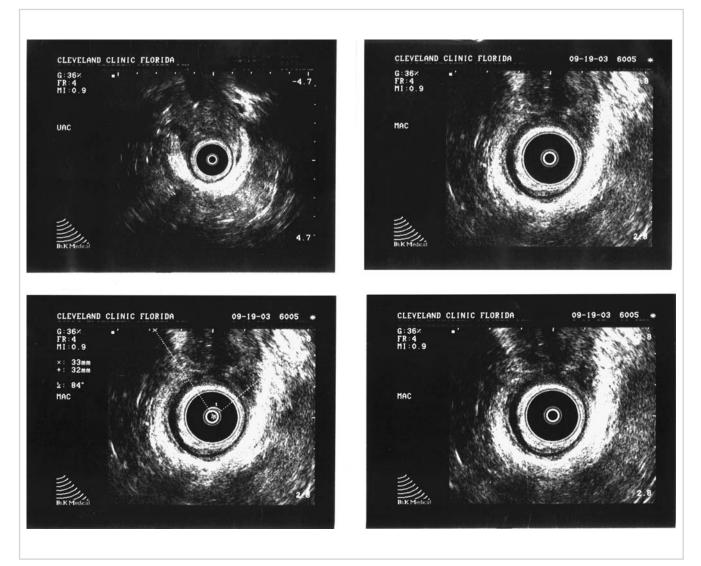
Endoanal ultrasounds.
